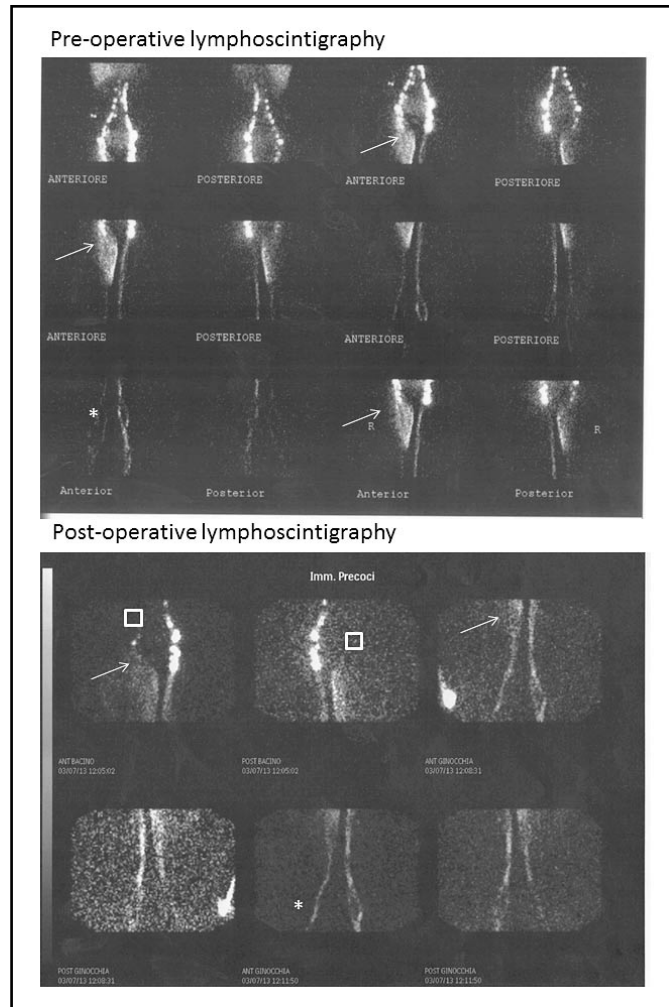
Lymphoscintigraphic pre(top) and post(bottom) operative assessment of LVA at the right groin. Arrows indicate dermal backflow (DB) below the groin on the patient's right side before and the reduction after microsurgery. Stars show the pre and post improvement of lymphatic flow in the right lower limb. Squares show the approximate site of LVA and the corresponding disappearance of the tracer where the lymphatics connect into the blood stream.
